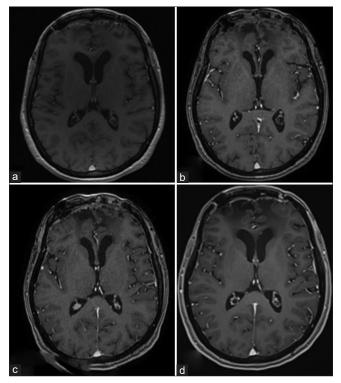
Follow-up head magnetic resonance imaging scans were performed at (a) 7 months; (b) 15 months; (c) 20 months; (d) 31 months post-surgery.
